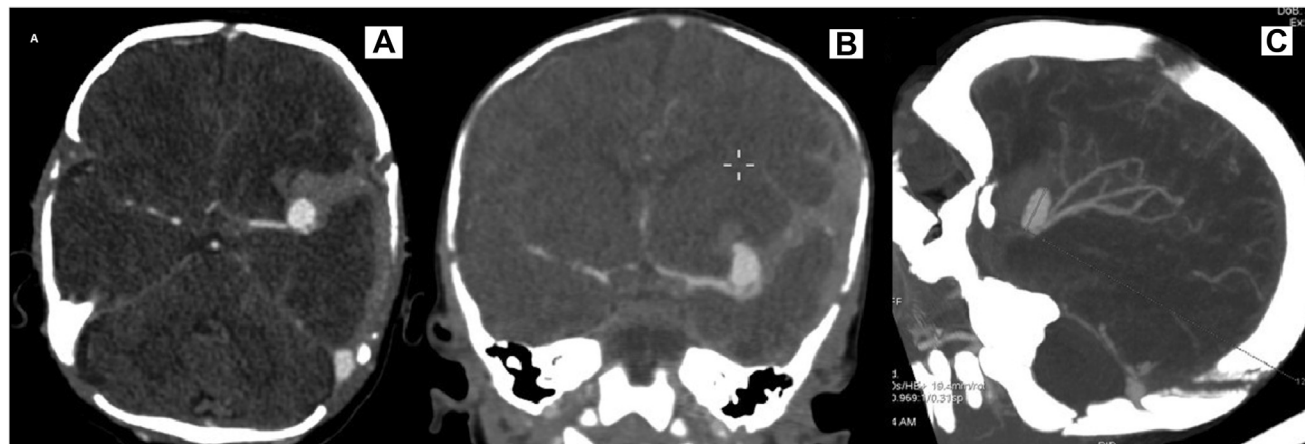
Contrast-enhanced computed tomography scan showing a left middle cerebral artery ruptured intracranial
